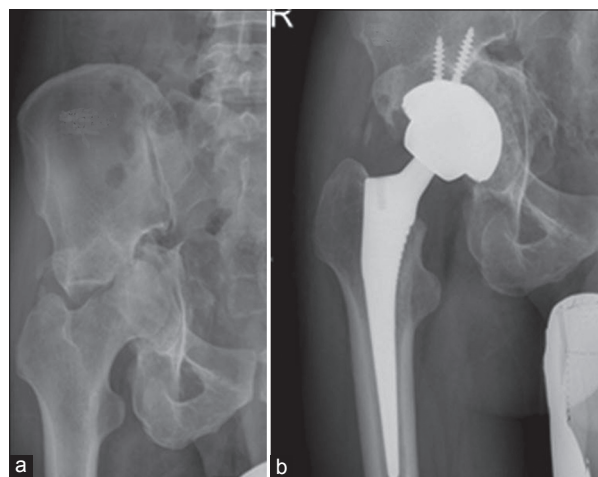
Preoperative X-ray showing (a) posttraumatic arthritis with large Paprosky type 2c defect in a 34-year-old male (b) postoperative X-ray at 1 year 6 months showing graft consolidation
